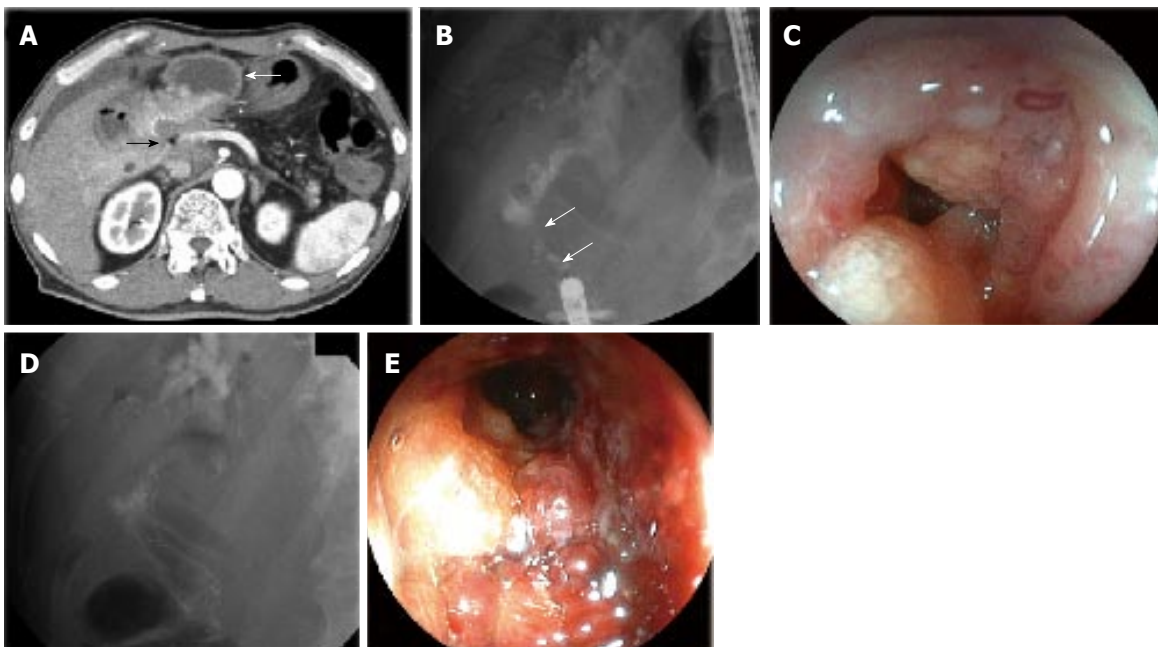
Metallic stent insertion with double-balloon endoscopy for malignant afferent loop obstruction in case 2. A: Computed tomography showed ascites, dilation of the afferent loop (white arrow), and a surrounding soft density (black arrow); B: The double-balloon endoscopy reached the afferent loop obstruction (arrows); C: Stenosis with irregular mucosa was seen; D and E: A Niti-S duodenal metallic stent with a diameter of 2.2 cm and a length of 6.0 cm was inserted and deployed.
